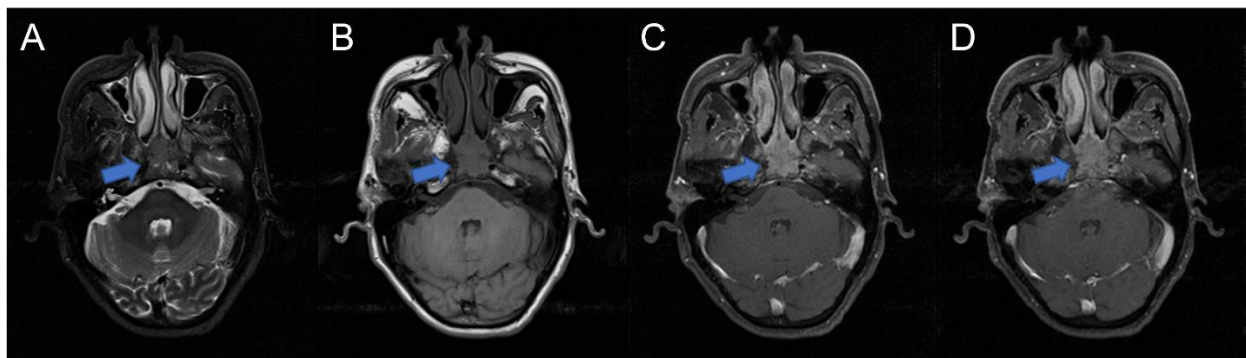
An example of VCE-MRI synthesis in a patient with head and neck cancer. A shows the T_2w MRI image. B shows the T_1w pre-contrast MRI image. C shows the real T_1w post-contrast MRI image. D shows the synthesized virtual T_1w post-contrast MRI image. The blue arrow shows the tumor position.
